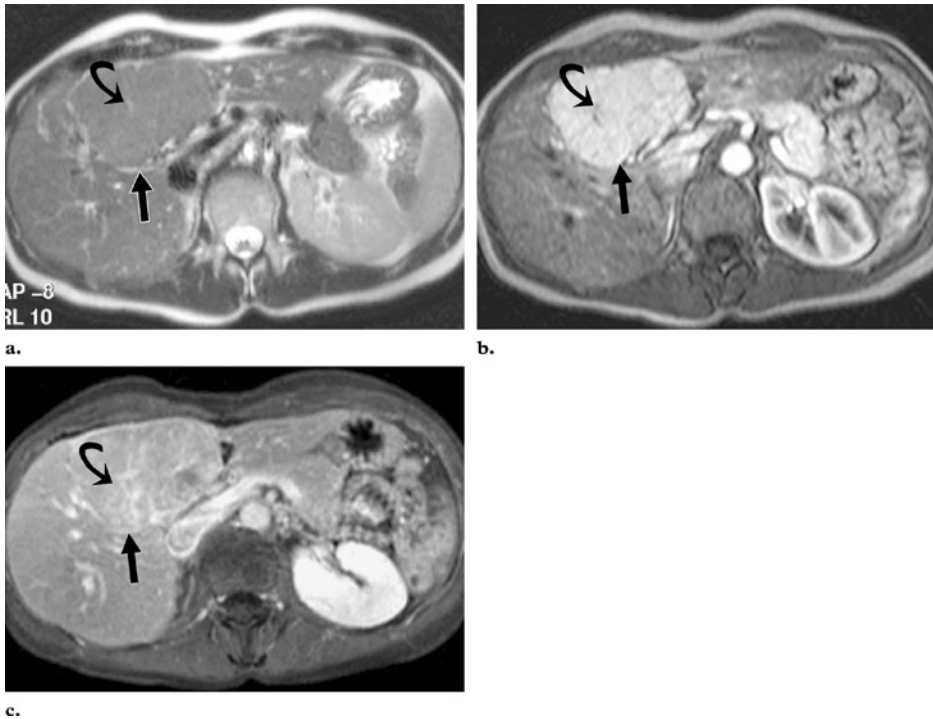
MR imaging appearance of typical FNH. a. Axial T2-weighted single-shot fast spin-echo (SE) image shows a large FNH lesion (straight arrow) that is isointense relative to the surrounding liver parenchyma. The central scar (curved arrow) has slightly higher signal intensity than the lesion. b. Axial gadolinium-enhanced 2D T1-weighted GRE image obtained during the arterial phase shows intense homogeneous enhancement of the entire lesion (straight arrow), except for the central scar (curved arrow). c. Axial gadolinium-enhanced 2D T1-weighted GRE image obtained during the portal phase shows that the lesion (straight arrow) has become isointense relative to the surrounding liver parenchyma, and the central scar (curved arrow) has enhanced.
